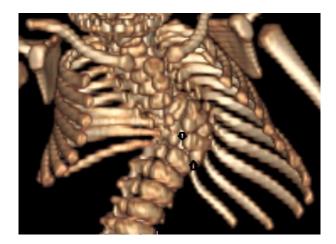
Volume rendered computed tomographic image of the trunk showing hemivertebra at T11 (up arrow), butterfly vertebra at T10 (down arrow), absence of right 9th & 11th ribs and Kyphoscoliosis.
